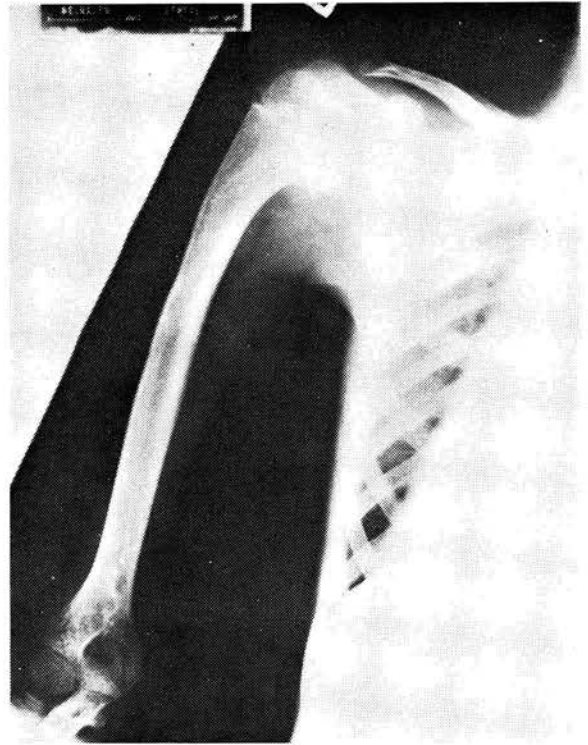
X-Ray shows a varus deformity of the head of the left humerus.
